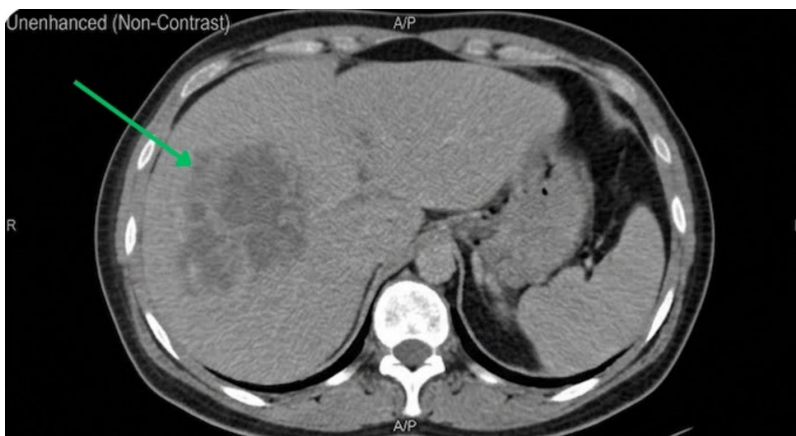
Unenhanced (non-contrast) axial CT image of the upper abdomen. A large heterogeneous hypodense lesion is visible in the right hepatic lobe (green arrow), demonstrating the mass before contrast administration.
